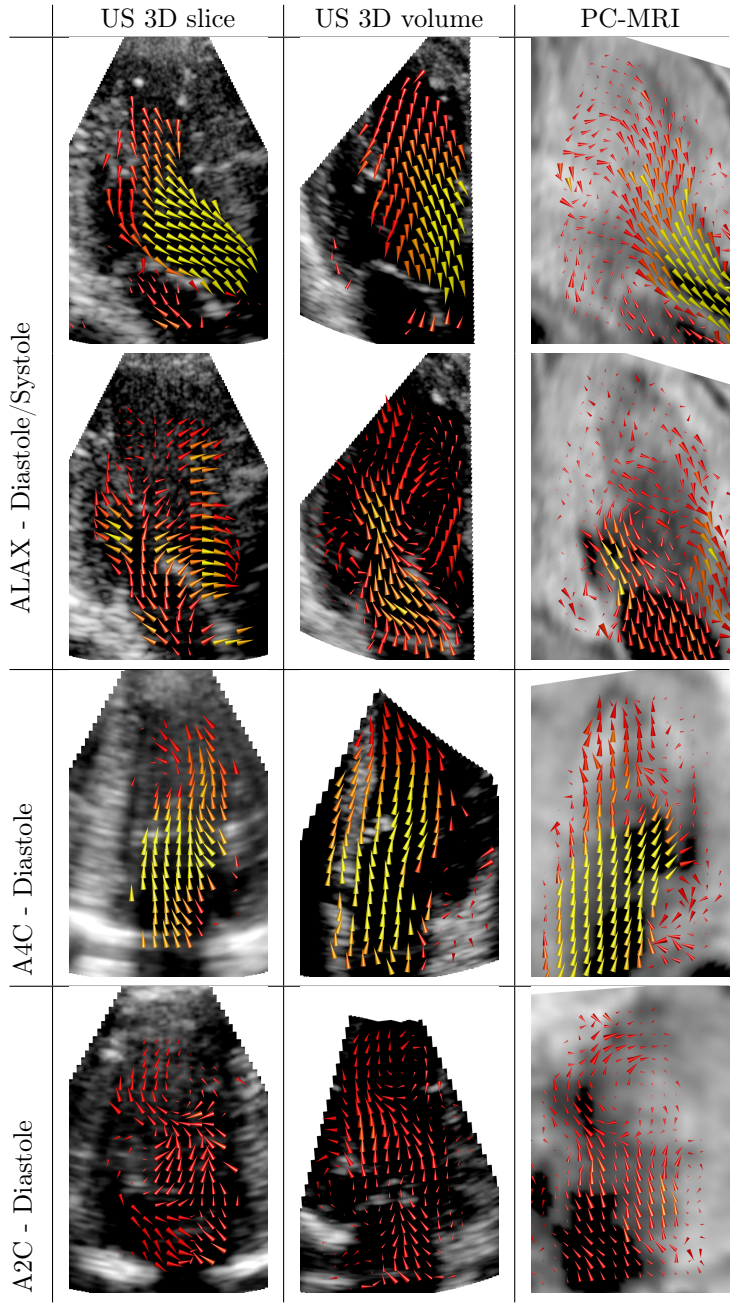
US 3D slice and volume and PC-MRI compared for a selection of views. Separate acquisitions were required for each US 3D slice view, while a single acquisition was sufficient for the US 3D volume acquisition as the desired views could be sliced from the full volume. The PC-MRI acquisition was acquired slice-by-slice in the long axis orientation.
